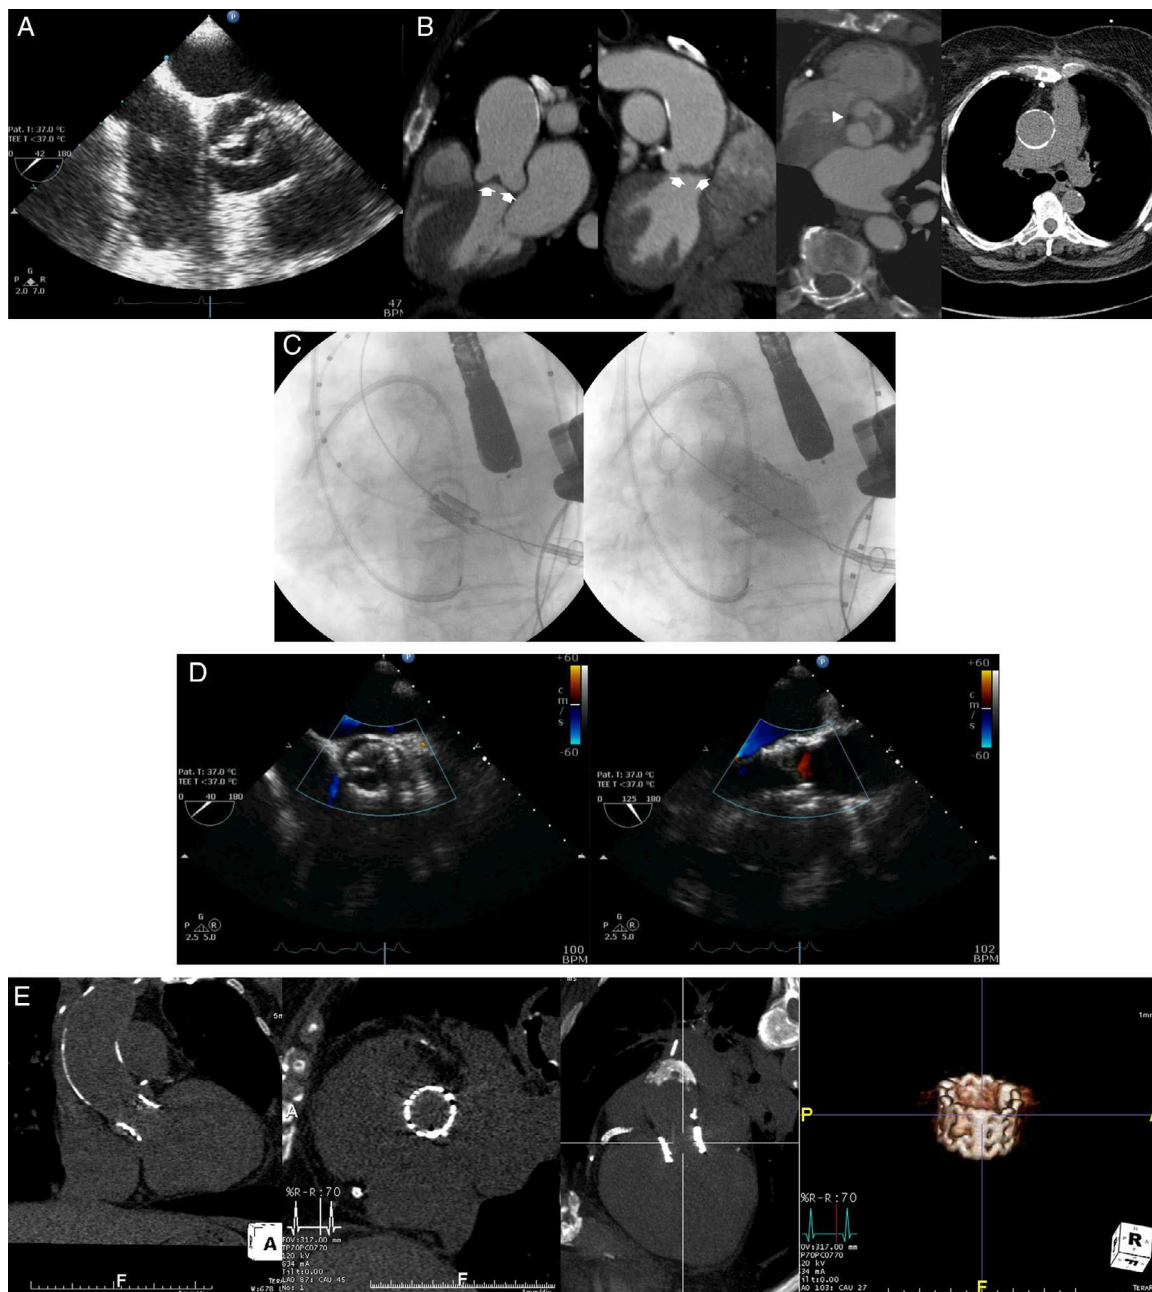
transesophageal echocardiography mid-esophageal aortic short axis view showing a noncalcific bicuspid aortic valve. B: computed tomography images assessing the aortic valve and ascending aorta: coronal oblique reconstructions showing the absence of calcium on the aortic valve and the severe thickness of the cusps (arrows) and double oblique transverse view showing the presence of a thick raphe (arrowhead) and the asymmetric opening of the aortic valve; axial view displaying a severe calcified ascending aorta. C: fluoroscopic images showing the positioning, using a pigtail catheter placed on the aortic valve as reference, and deployment of a 26-mm balloon-expandable valve by transapical approach. D: postprocedural transesophageal echocardiography mid-esophageal long-axis and short-axis views showing the absence of residual aortic regurgitation. E: 30 days post implantation computed tomography coronal and sagittal views, coronal oblique reconstruction views and volume-rendered image showing the complete expansion and correct positioning of the stent valve.
